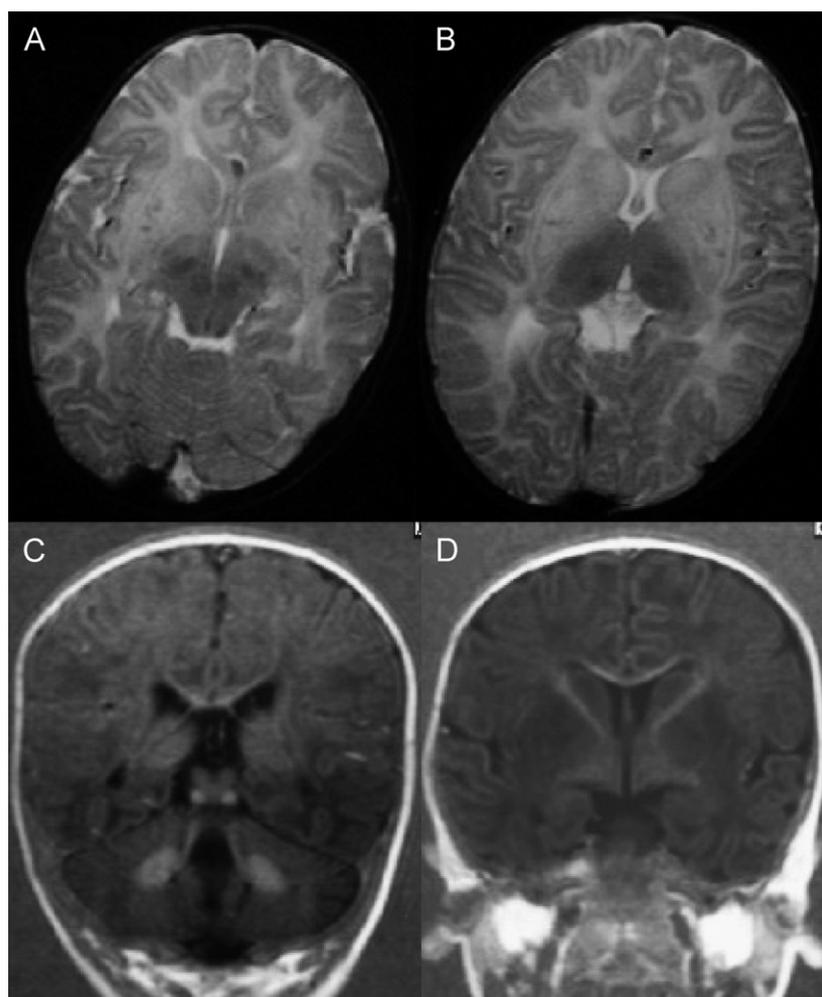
MRI of a child with Sandhoff disease with hyperintensities in (A,B) axial T2-weighted images of periventricular, frontal, and occipital white matter as well as in (C,D) coronal T1-weighted images of white matter and cerebellum (dentate nuclei).
